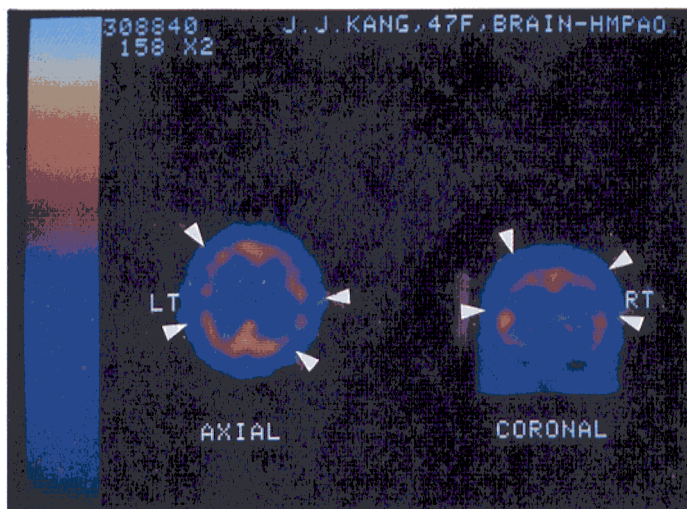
HM-PAO brain SPECT image of patient 2, demonstrated bilateral hypoperfusion in the parietal and temporal cortex.
